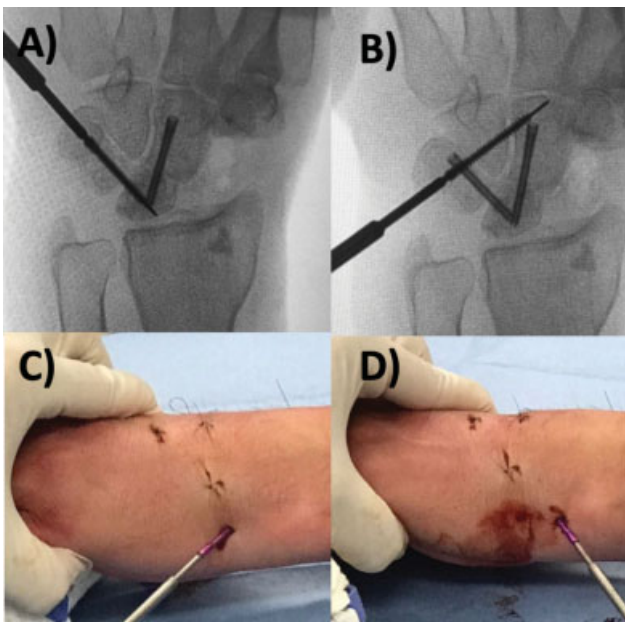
Fixation with triquetrum-lunate and triquetrum-hamate-capitate screws. (A) Intraoperative anteroposterior fluoroscopy showing the triquetrum-lunate screw. (B) Intraoperative anteroposterior radiography of the wrist showing the triquetrum-hamate-capitate screw. (C) Intraoperative clinical image of the fixation of the triquetrum-lunate screw. (D) Intraoperative clinical image of the fixation of the triquetrum-hamate-capitate screw.
